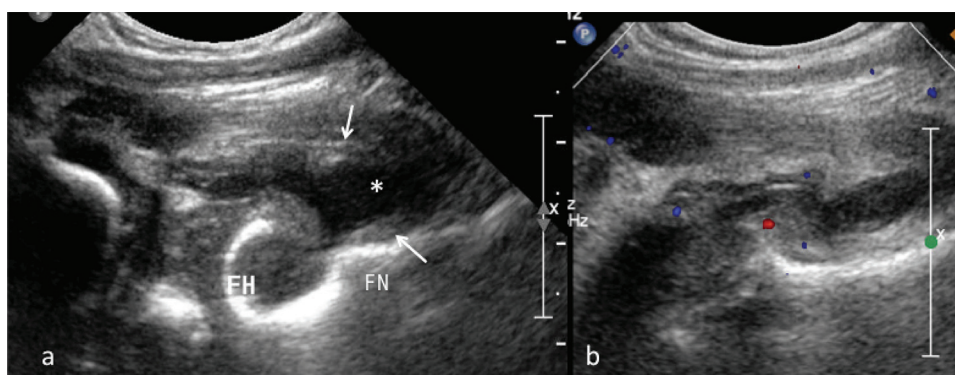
Septic arthritis in a 7-month-old boy with a 1-month history of limit range of motion of the right hip and fever. (a) Longitudinal US scan using curvilinear transducer over the anterior aspect of the right hip shows thickening of the hyperechoic synovial tissue (arrow) and joint effusion (*) anterior to the right femoral head (FH) and neck (FN). (b) Color doppler image shows mild-degree synovial hyperemia. The diagnosis was confirmed by arthroscopy.
